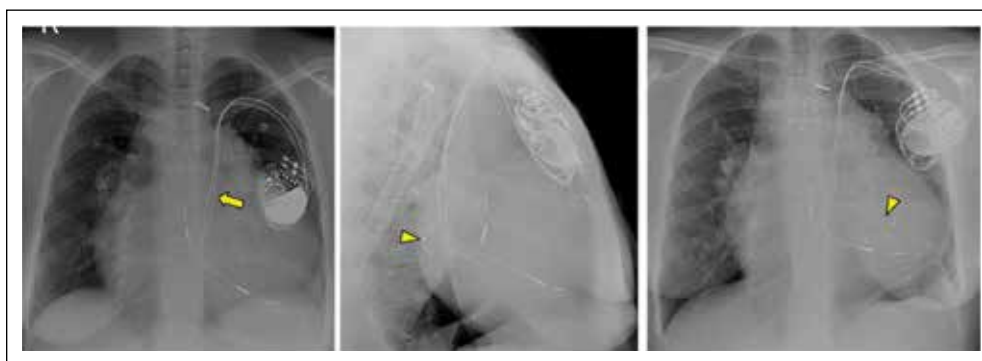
This frontal and lateral chest radiographs of a patient who underwent pacemaker insertion for complete heart block, the course of leads through left SVC seen (this can be recognised by the the presence and course of leads to the left of spine) (arrow) (A), as the patient developed pacing-induced cardiomyopathy and worsening of LV dysfunction later device was upgraded to CRT-P with an additional LV lead (arrow-head) implanted through LSVC.
